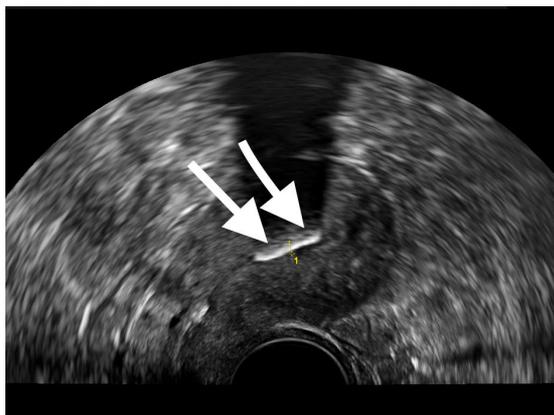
2D endovaginal examination-longitudinal plane ultrasound- linear hyperechoic structure with posterior acoustic shadowing in the uterine cavity.
